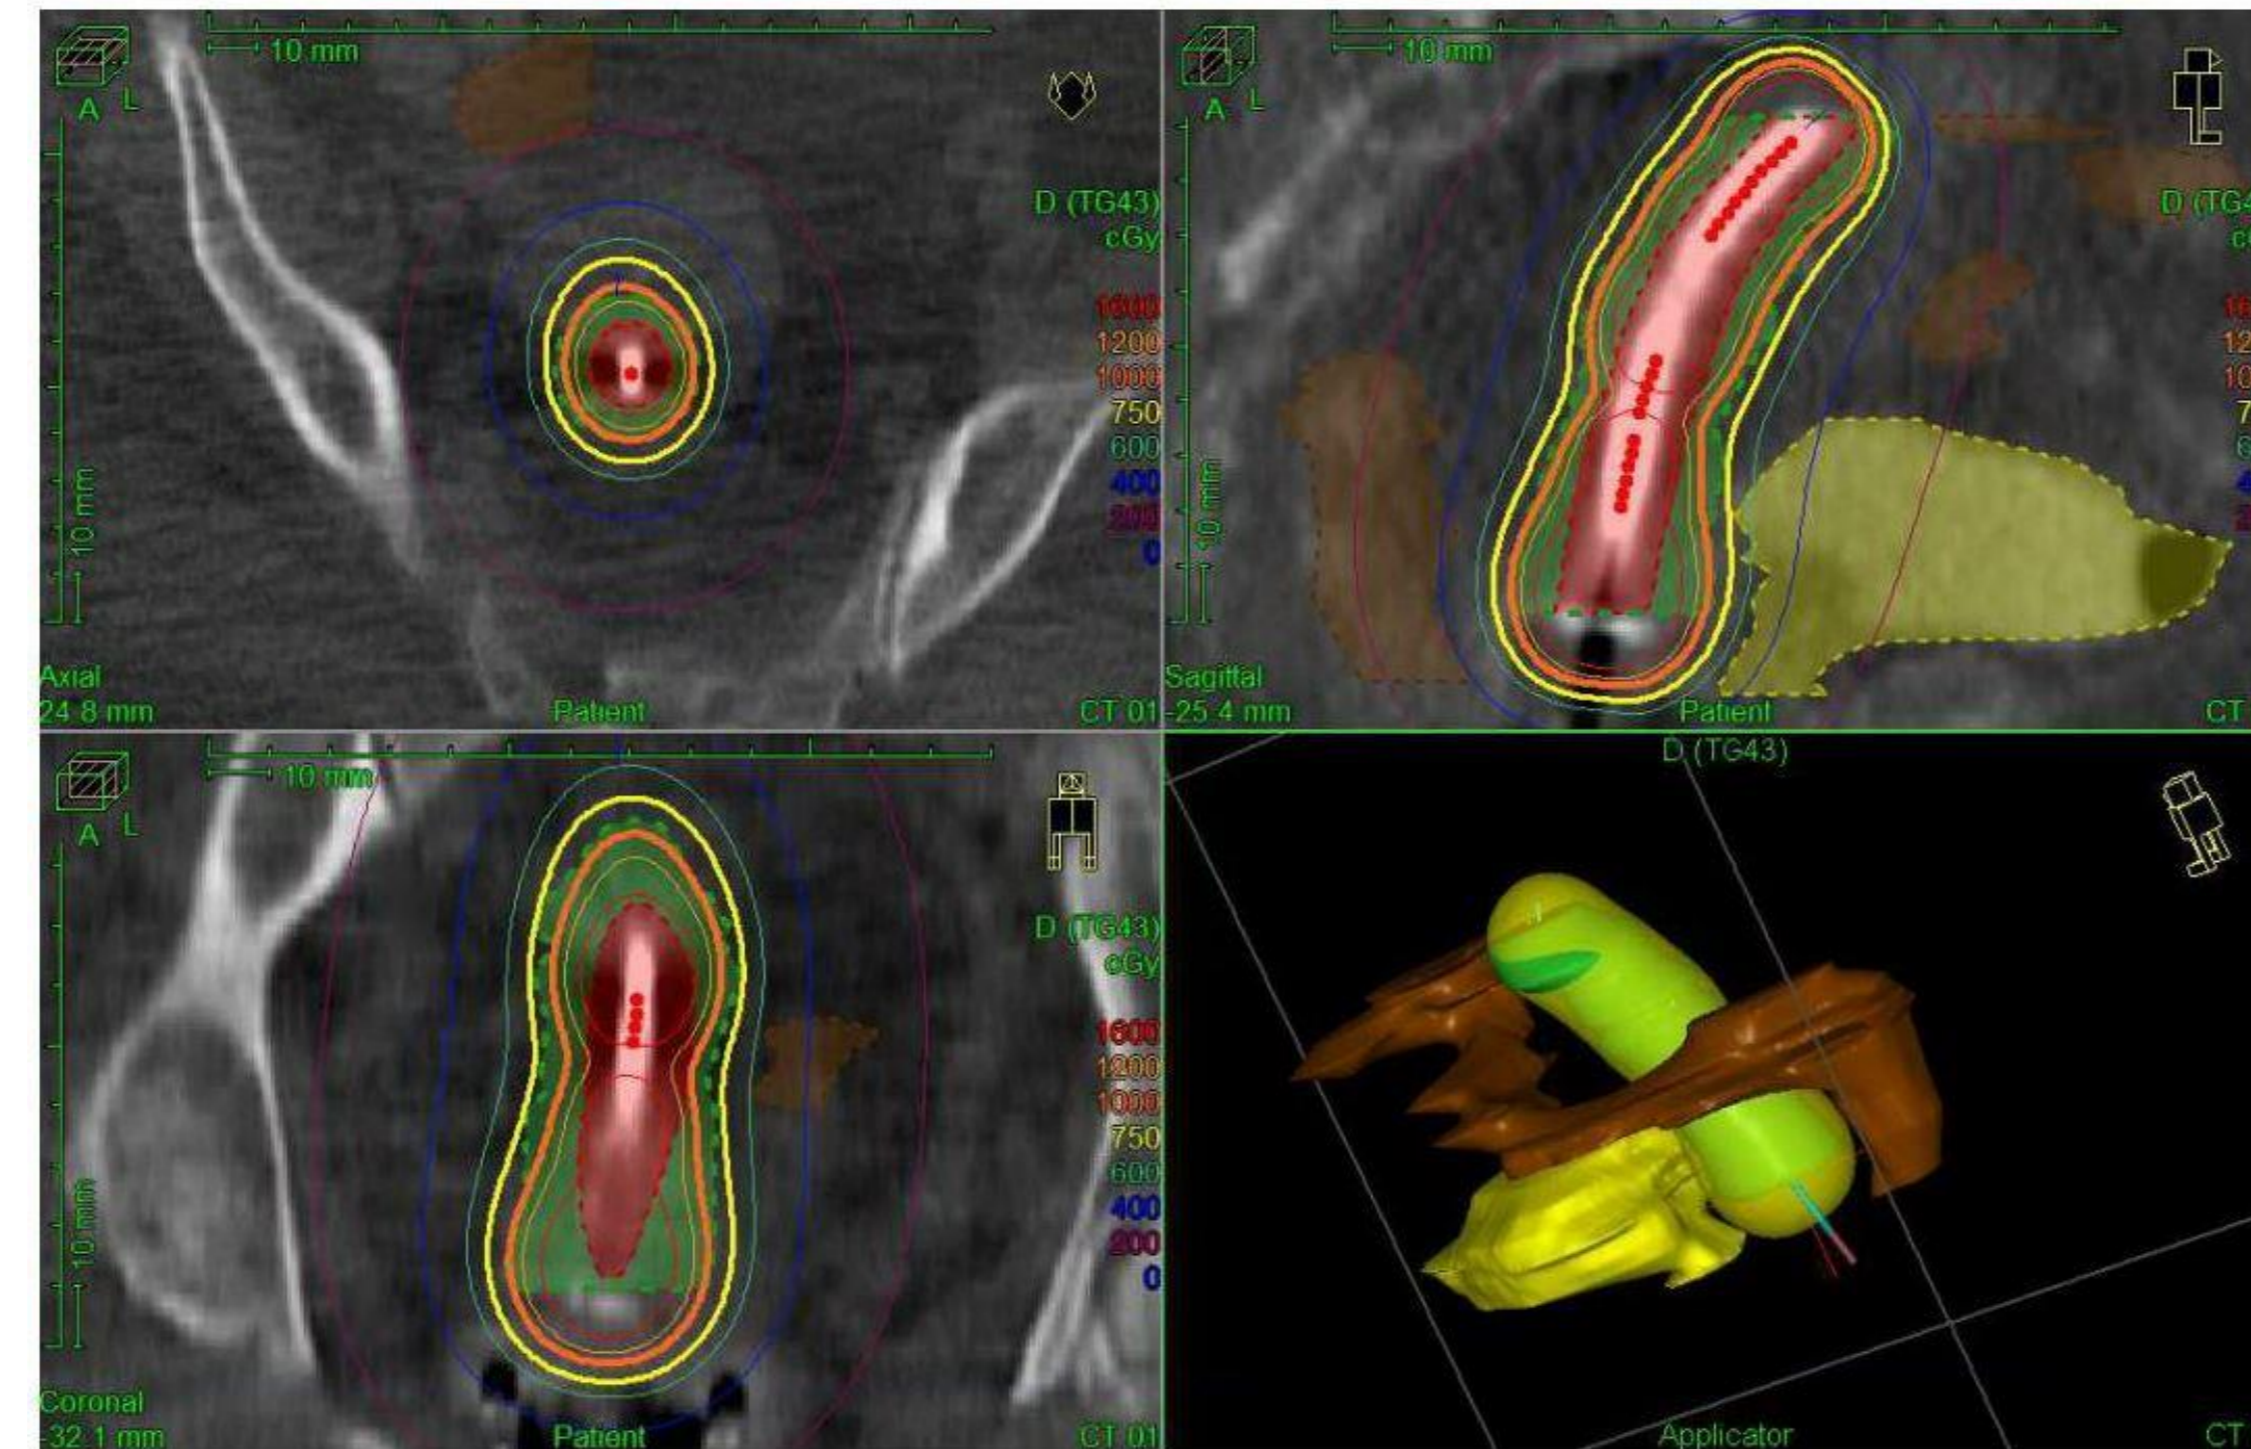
Sample CT-guided dose distribution plan with (clockwise from top left) transverse image, sagittal reconstruction, coronal reconstruction, and 3-D reconstruction. GTV is marked in red, CTV in light green, bowel in brown, and bladder in yellow. Isodose lines are also shown—Red=160%, Orange=120%, and Yellow=100%. The transparent 100% isodose cloud encompassed most of CTV in 3D display.
